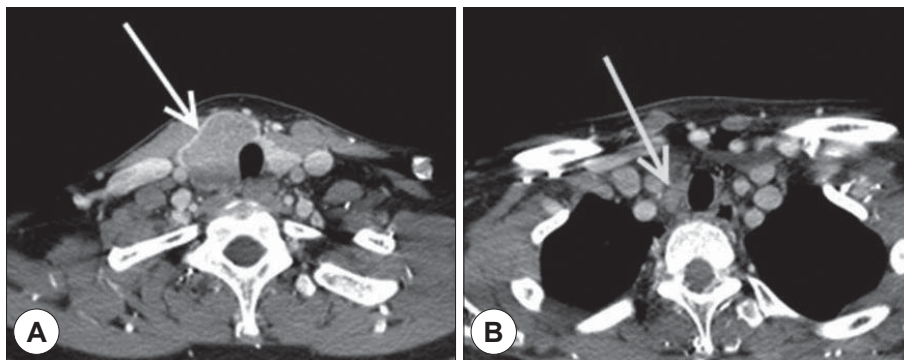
A : Axial-enhanced CT scan reveals a well defined low density mass at right lobe & isthmus of thyroid gland(arrow). B : CT scan shows lymph node enlargement at right paratracheal area(arrow).
